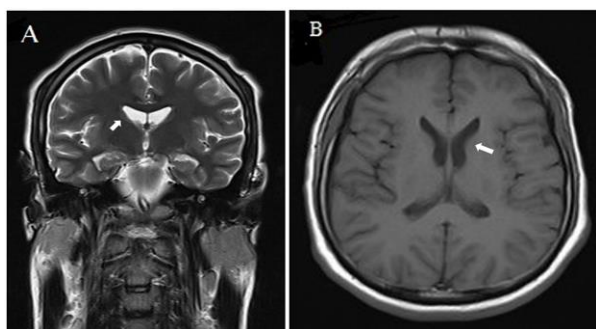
A) Coronal T2-weighted and B) axial T1-weighted magnetic resonance images showing bilateral atrophy of the caudate (arrows)
